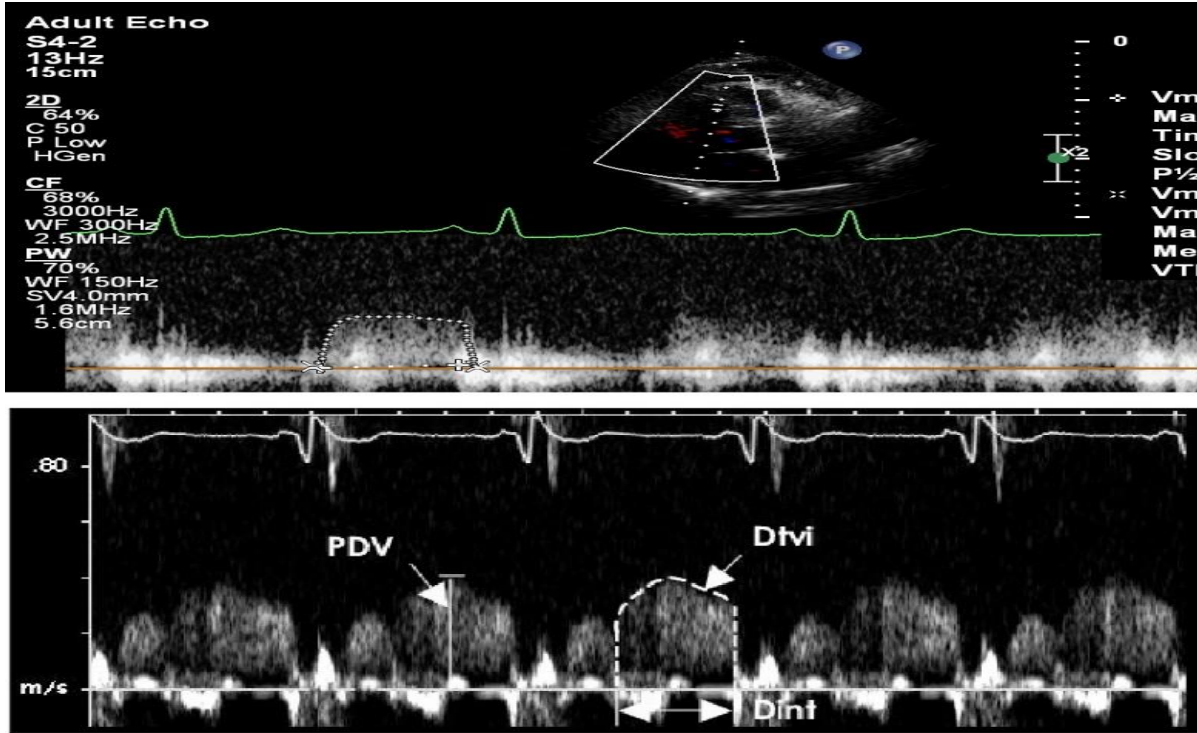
Echocardiography was performed with a Phillips echocardiography machine (affinity 50) so that the patients were in the left decubitus position and the short axis echo view of large vessels. With a brief rotation of the probe, the passage of the LAD under the pulmonary artery is evident. Its flow was evaluated by the pulsed wave Doppler.
